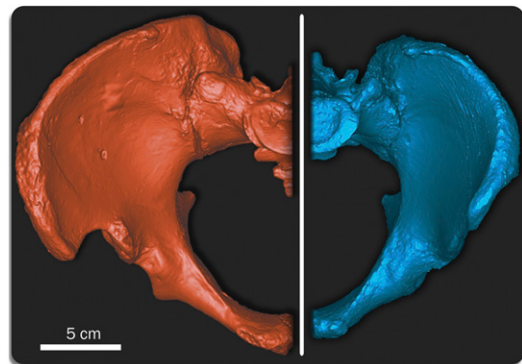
Surface renderings showing the SH Pelvis 1 (Left, surface scan) vs. an anatomically modern male (Right, CT scan) of similar articular size in superior view, demonstrating the primitive (Left) vs. derived (Right) pelvic morphology within the genus *Homo*. SH Pelvis 1 vs. modern male dimensions: vertical acetabular diameter, 58.8 mm vs. 57.0 mm; maximum transversal sacral plate diameter, 52.3 mm vs. 51.5 mm; sagittal sacral plate diameter, 31.4 mm vs. 33.9 mm. Alignment of both elements was done using an 8 landmark registration algorithm in Mimics 13.0 (Materialise).
